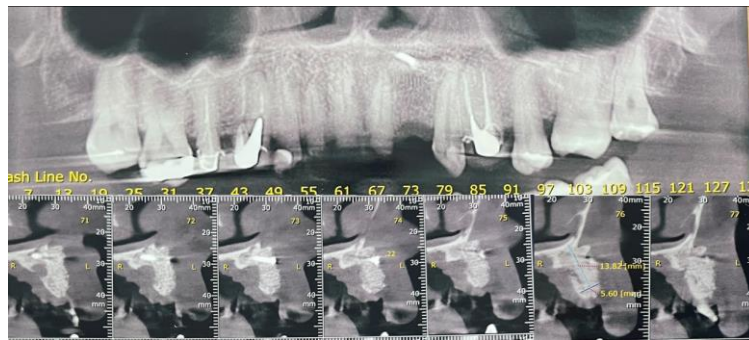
New CT scan after 180 days.
